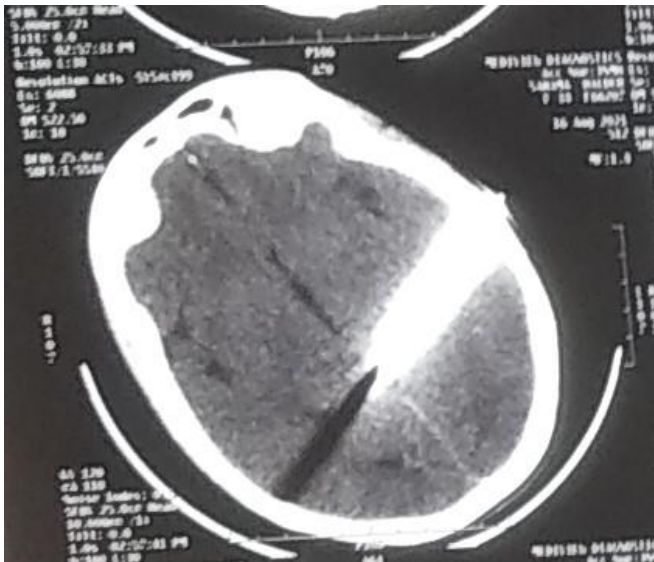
Plain Pre OP CT Scan Brain (Brain Window) Not Showing any Obvious Intra Parenchymal Haemorrhage or Contusion
